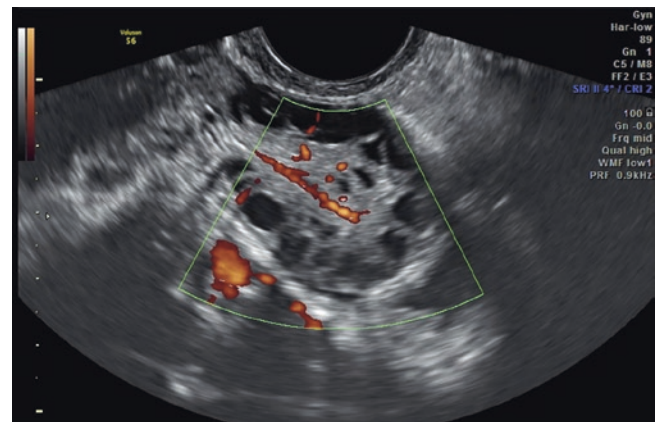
Transvaginal Doppler sonogram of polycystic ovary shows an increased intra-ovarian stromal vascularization
